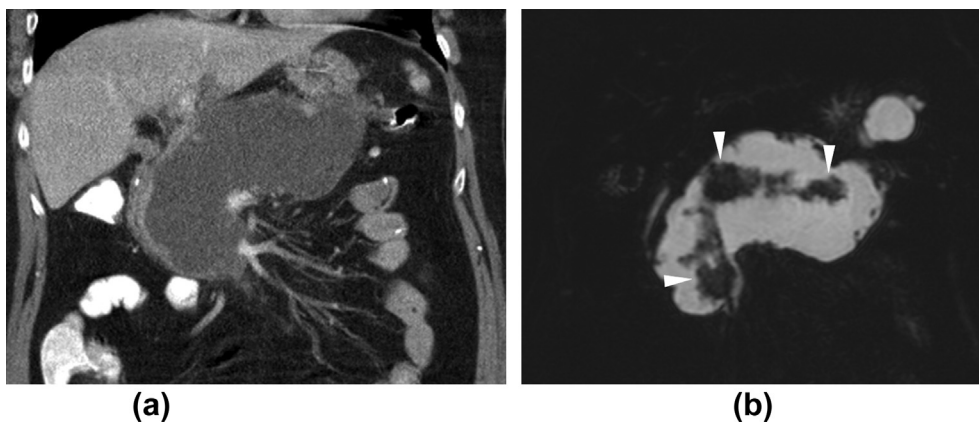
Differentiating liquid from a necrotic collection. (a) Coronal reformatted contrast-enhanced CT image shows a homogeneous pancreatic collection. The corresponding heavily T2-weighted sequence nicely depicts the exact composition of the collection: a necrotic pancreas (arrowheads) surrounded by clear fluid (WON).
